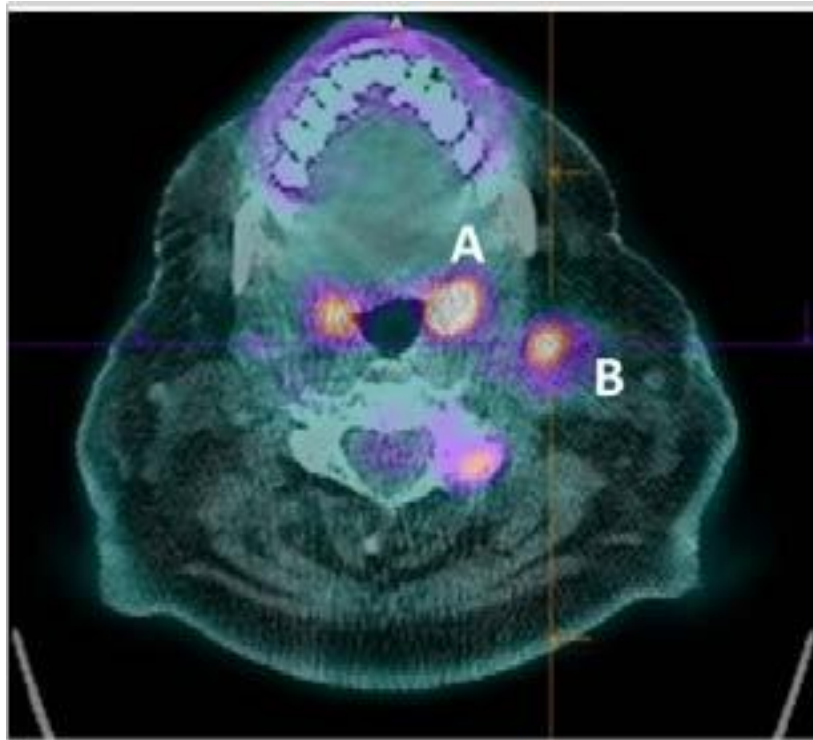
TEP-TDM au 18FDG A) hypermetabolisme intense de l'amygdale gauche (SUVmax=14) B) adénopathie sous digastrique gauche (SUVmax=6).
